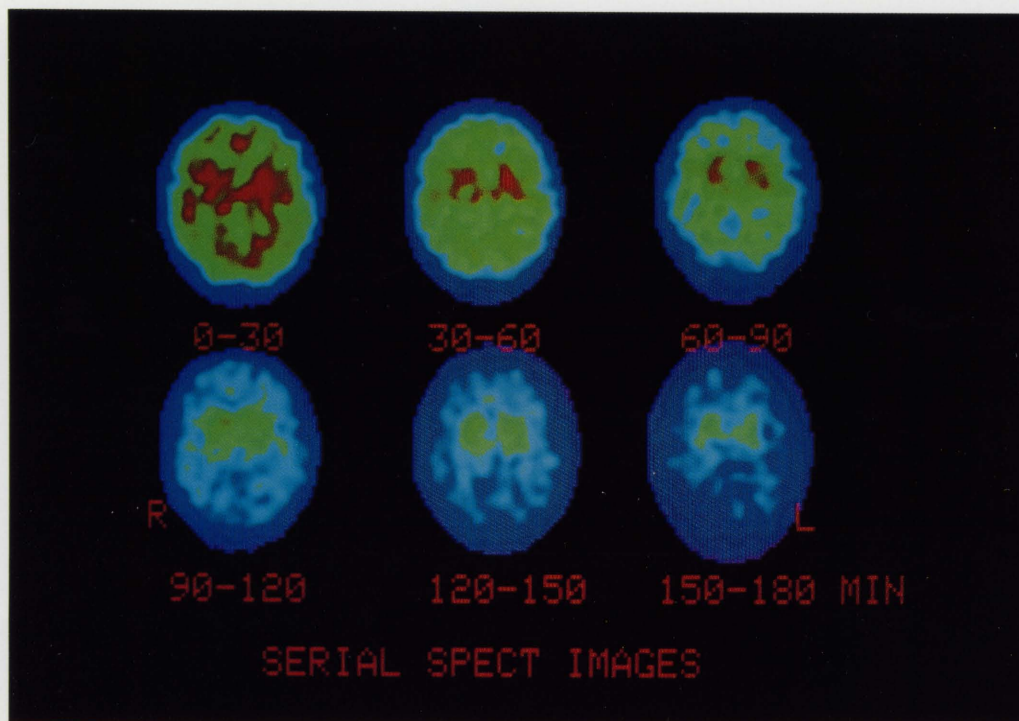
Six serial SPECT scans of a normal volunteer each with a 30 minute acquisition.
